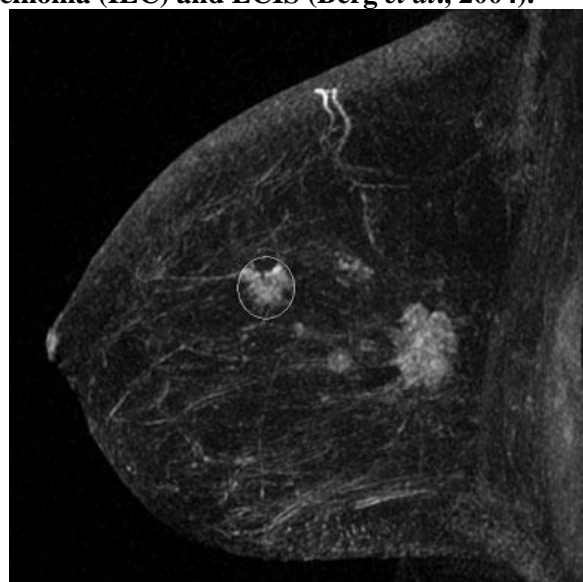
Contrast-enhanced MRI of the same patient, a 43-year-old female with a nodular density on screening mammography and ultrasound, revealed the confirmed index cancer, which was larger on MRI than other imaging, along with a second, smaller mass (circled), situated approximately 5 cm further anteriorly and laterally than the index malignancy. A mastectomy was performed on this patient (Berg *et al.*, 2004).
